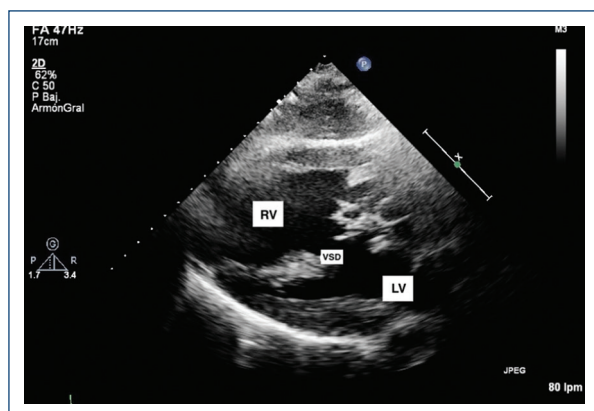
Transthoracic echocardiogram, long paraesternal axis view. Large ventricular septum defect, 37 mm.
